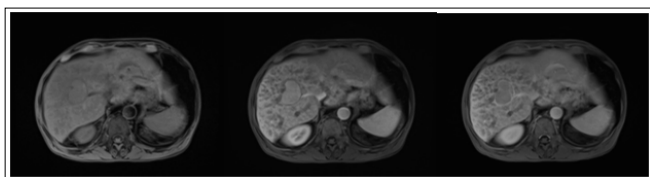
MRI with T1 Pre-Contrast, Arterial Phase, and Venous Phase Demonstrate an Arterially Enhancing Mass in Segment 7/8 with Washout and Enhancing Pseudo Capsule, LI-RADS 5.
